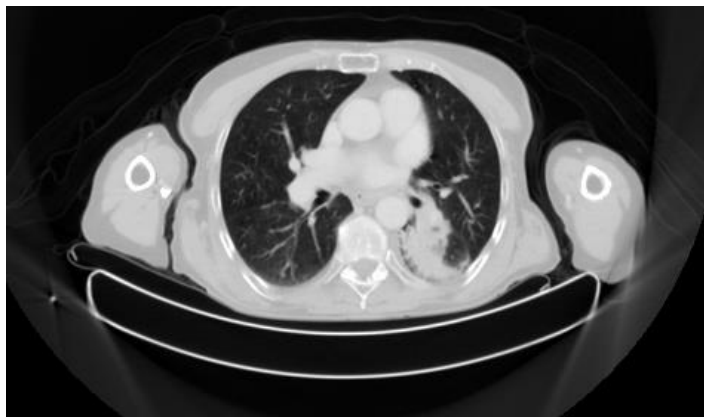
The CT image of the lung field from a NSCLC patient (data description detailed in Chapter 5).
